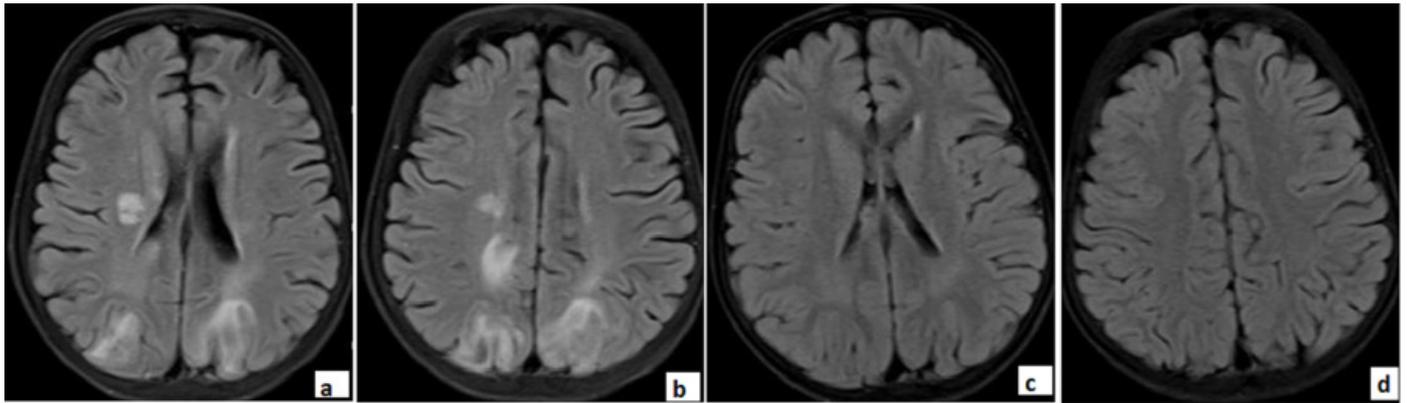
In the 15-year-old female patient who underwent liver transplantation due to oxalosis, the hyperintense foci, which on the axial FLAIR image can be observed in Figure 3a and 3b, at the bilateral parietooccipital cortical, subcortical white matter, right parietal periventricular white matter in the brain MRI performed after transplantation, and which are compatible with PRES seems to have disappeared on the control brain MRI (Figure 3c, 3d).
